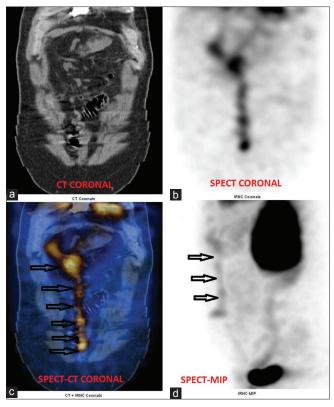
(a-d) Single-photon emission computed tomography-computed tomography images confirm that linear area of increased tracer uptake seen in single-photon emission computed tomography images extending from liver to umbilicus actually correlate with the umbilical varices (see arrows)
